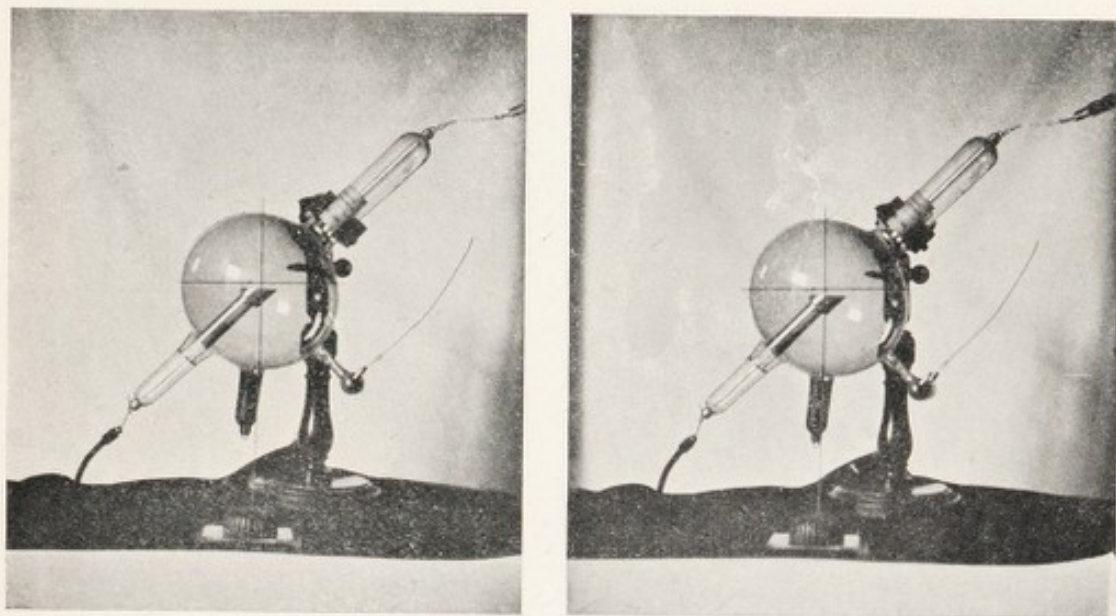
STEREOSCOPIC VIEW OF X-RAY TUBE WITH WIRE CROSS IN POSITION.
